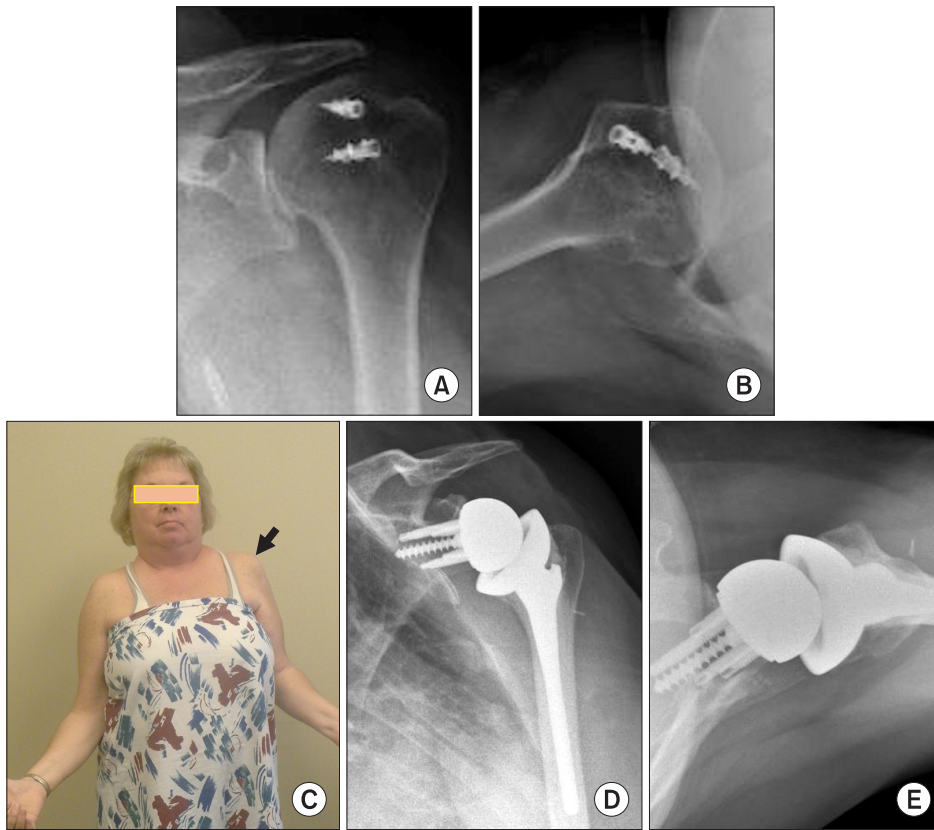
A 47-year-old female patient with history of failed rotator cuff repair. (A) Preoperative conventional anteroposterior radiograph of the shoulder shows proximal migration of the humeral head. (B) Preoperative conventional axillary radiograph of the shoulder shows the humeral head has migrated anteriorly. (C) Deltoid atrophy (arrow) was evident in the preoperative physical examination. Conventional radiographs at 1 month follow-up show a well-fixed prosthesis: (D) anteroposterior view, and (E) axillary view.
